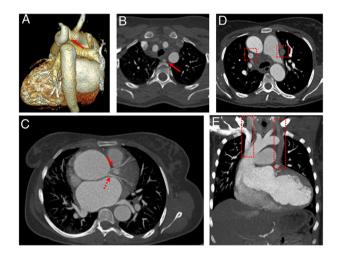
Posterior view 3D volume rendering CT angiography image (A) and axial CT scan in mediastinal window (B) show a coexistence of the aberrant right subclavian artery (Iong arrow) and aortic coarctation. The aberrant right subclavian artery originates from the aortic coarctation segment. Axial CT scan (C) reveals the circumflex artery (dashed arrow) and left descending coronary artery (short arrow) originating from aorta directly. Axial (D) and coronal (E) CT angiography scans show a double superior vena cava anomaly (frames). All CT scans also reveal cardiomegaly and ascending aortic aneurysm.
